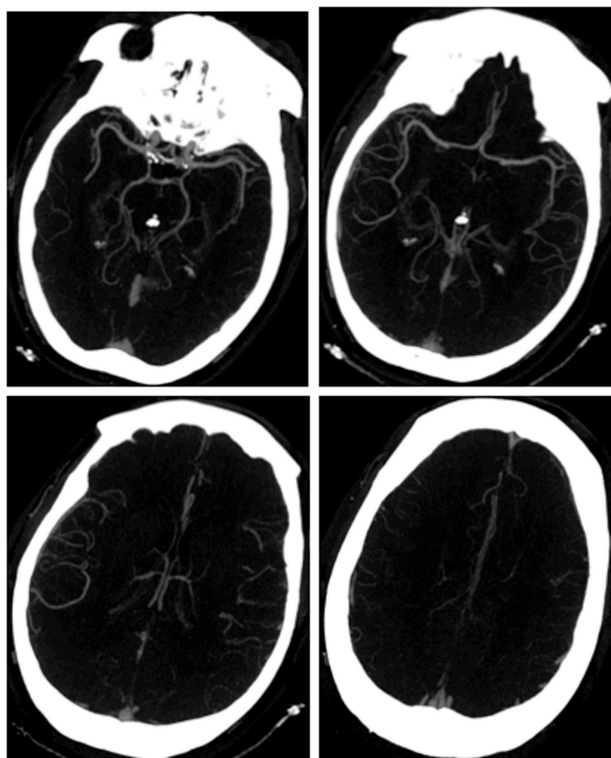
Multiple cuts of the initial CT angiogram at presentation showing an evidence of vasospasm.
